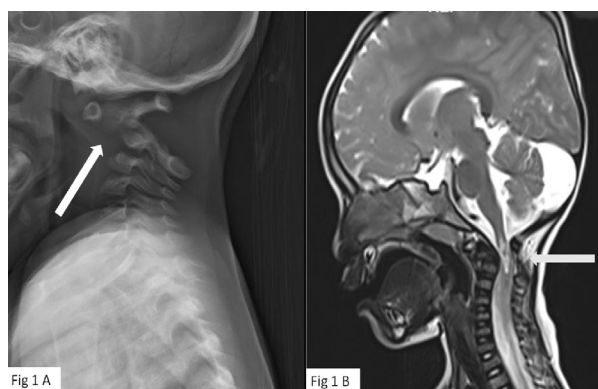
(a) X-ray Cervical spine lateral view flexed position showing widened pre-dentate space (white arrow); (b) MRI T2 weighted image sagittal section showing compression of the cord at C1 level (grey arrow).
